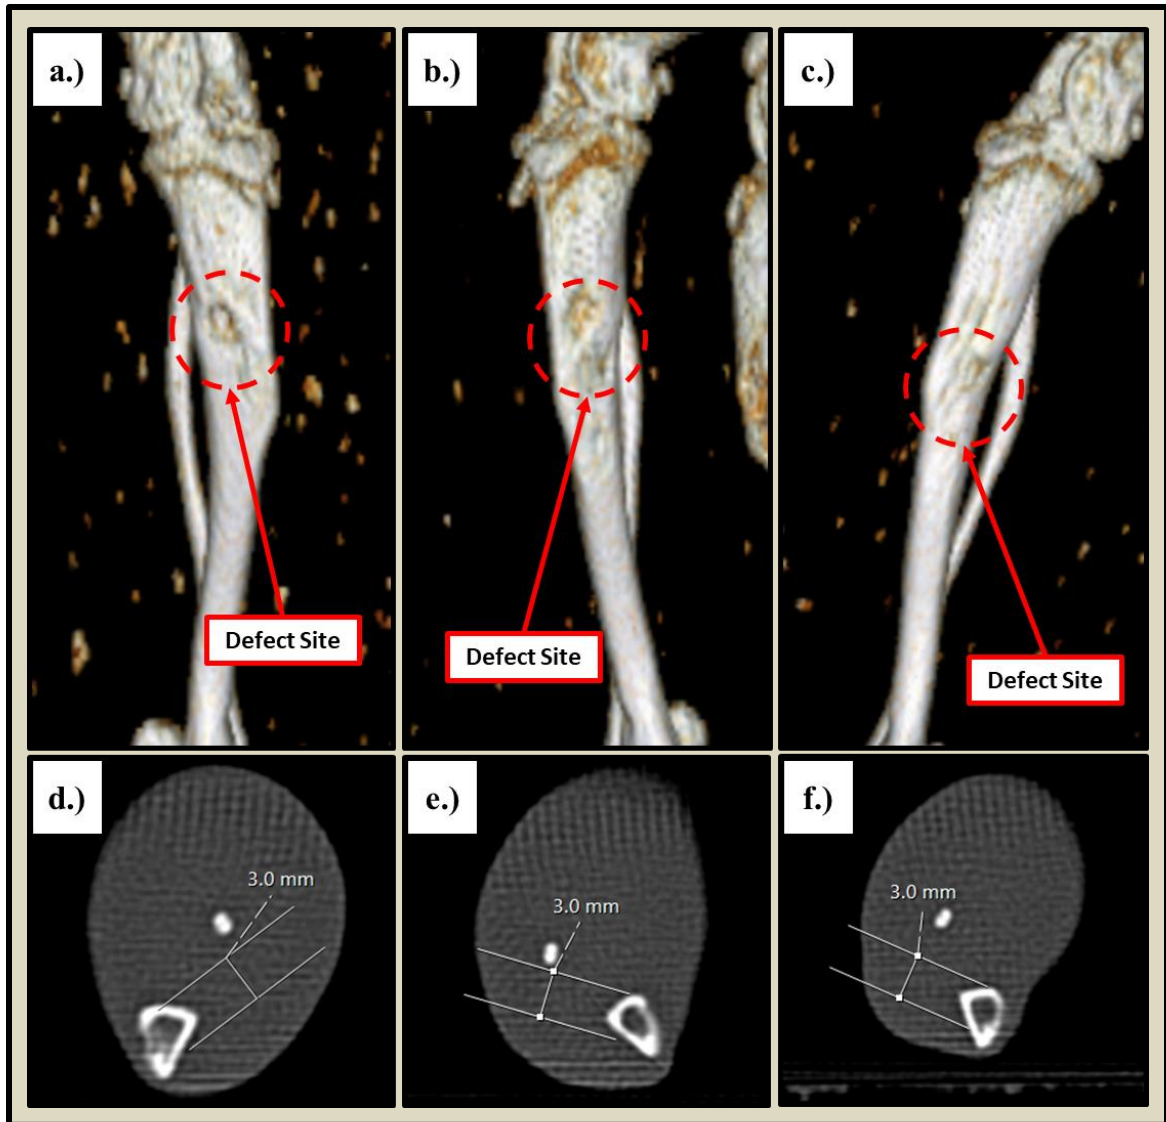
CT 3D renders (a-c) and cross-sectional images (d-f) for injectable design treated tibial defects. Veragraft® (a,d), I-1 (b,e), and I-2 (c,f) treated defects (b,d) are shown.
